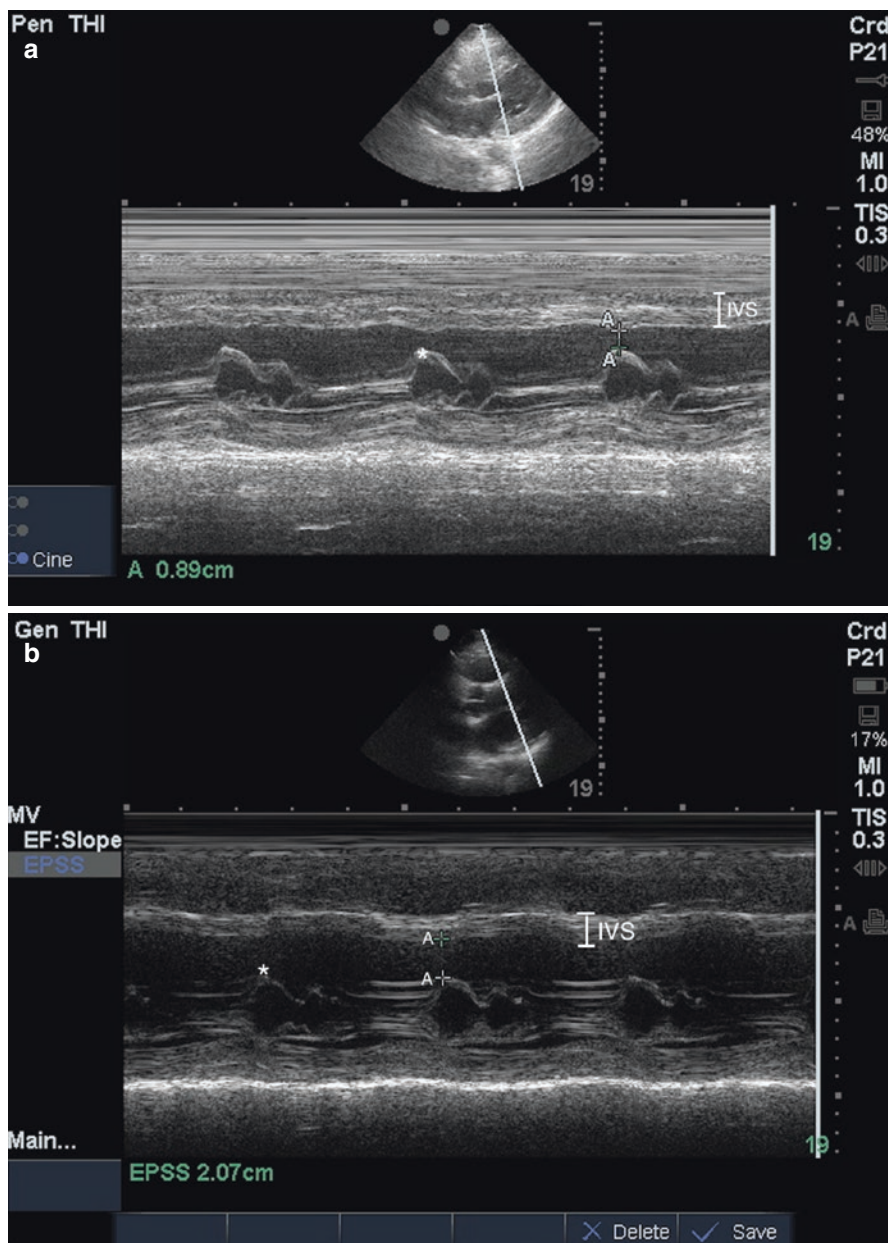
(a, b) (EPSS normal, abnml). End point septal separation (EPSS) is the use of M-mode in the parasternal long cardiac window to evaluate the distance between the anterior leaflet of the mitral valve and the interventricular septum in end diastole. EPSS >1.2 cm is considered abnormal and is associated with poor ejection fraction. *IVS* interventricular septum, * Anterior mitral valve leaflet, A-A EPSS
